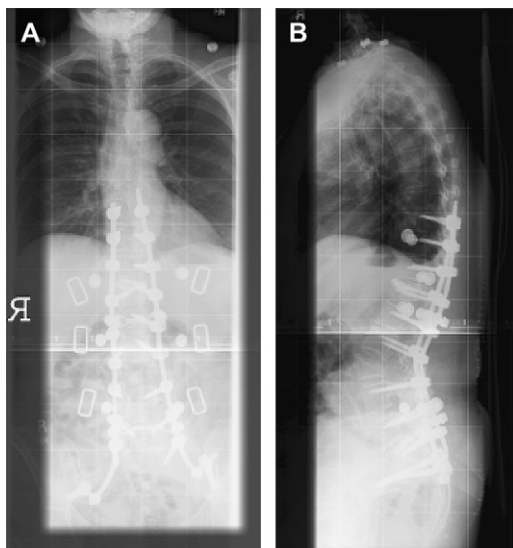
(A) Anterior-posterior radiograph demonstrates coronal correction of scoliosis. (B) Sagittal radiograph after L3 pedicle subtraction osteotomy was performed with posterior fixation from T9 to the ilium.
